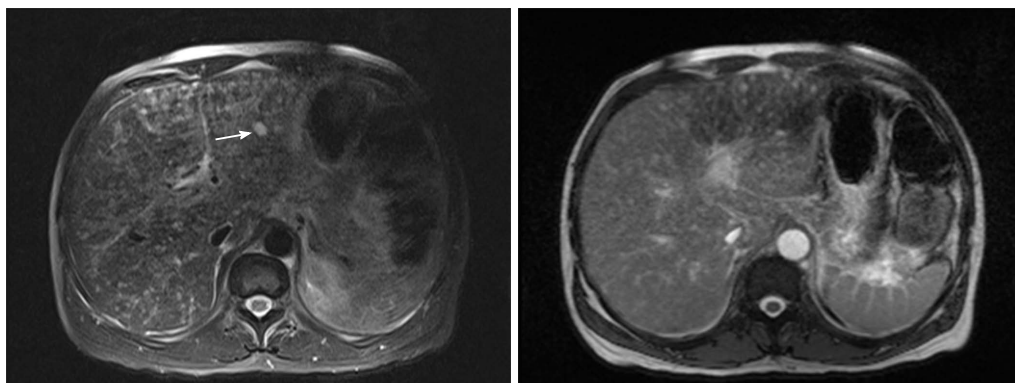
SPAIR and T2 images Kaposi sarcoma on magnetic resonance imaging.
